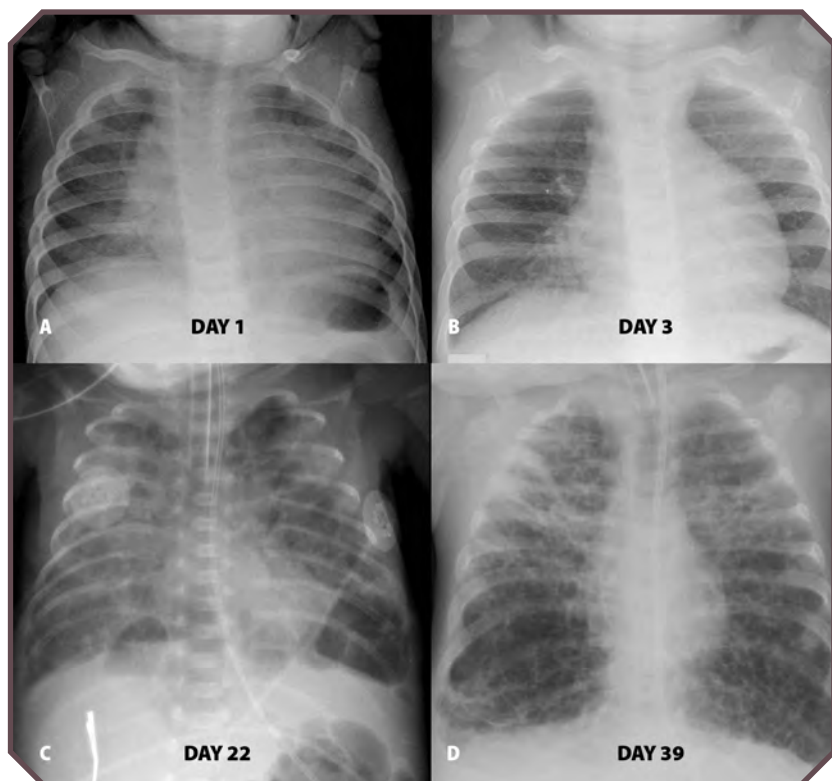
Progression of bronchopulmonary dysplasia (BPD) radiographic findings (frontal views) in a premature neonate. A. Radiograph with normal findings was obtained on day 1, after birth. B. Respiratory distress syndrome is typified by diffuse, homogeneous, “ground-glass” opacities seen on day 3 after birth. C. Moderate BPD changes on day 22 after birth show hyperinflation with patchy atelectasis. D. Severe BPD changes on day 39 after birth are characterized by extensive, diffuse cystic areas and hyperinflation.
